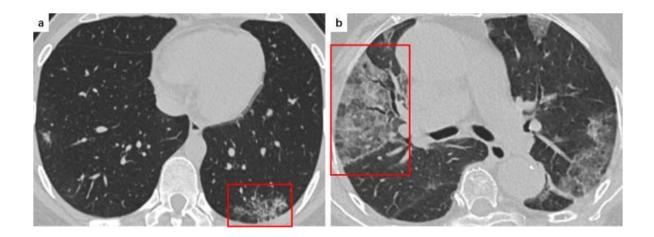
A 34 year old patient with COVID-19 symptoms.a: reticular pattern can be seen in the left lower lobe and subpleural area of the lungs(red frame) using a CT scan, b: An 81-yearold patient with COVID-19 patient. CT scan shows reticular pattern superimposed on the background of GGO, resembling the sign of crazy paving stones in the right middle lobe (red frame) (Ye, Zhang et al. 2020).
